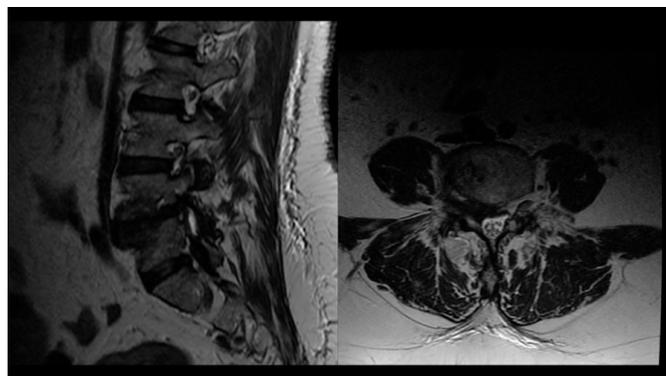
Preoperative MRI showing grade II DSL with right L4-L5 foraminal stenosis.
